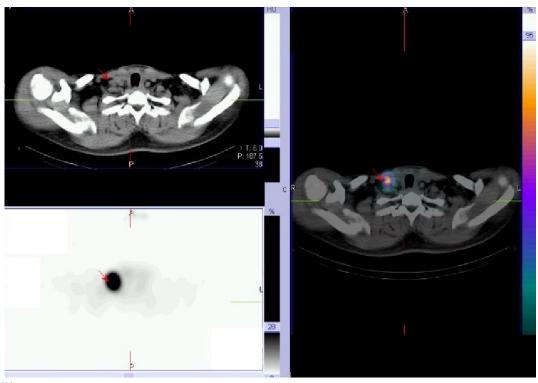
$I^{131}$  whole-body cancer workup with neck single-photon emission computed tomography/computed tomography seven days after taking 120 mCi of the agent revealed multiple foci of increased radioiodine uptake in the midline of the anterior neck (thyroglossal duct remnant) and right neck (level III).
